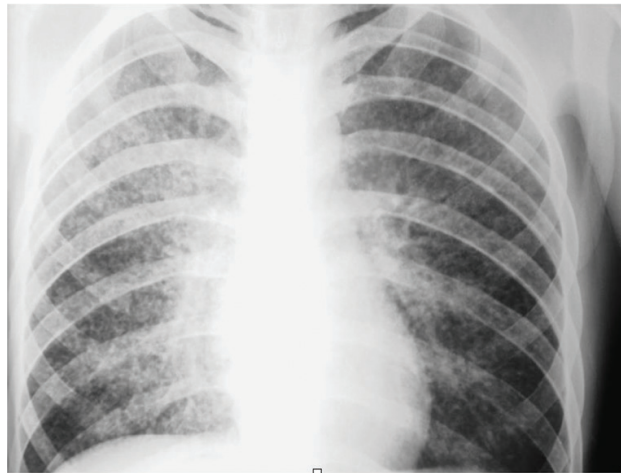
Chest radiograph showing diffuse micro-nodular infiltrates in both lung fields.
